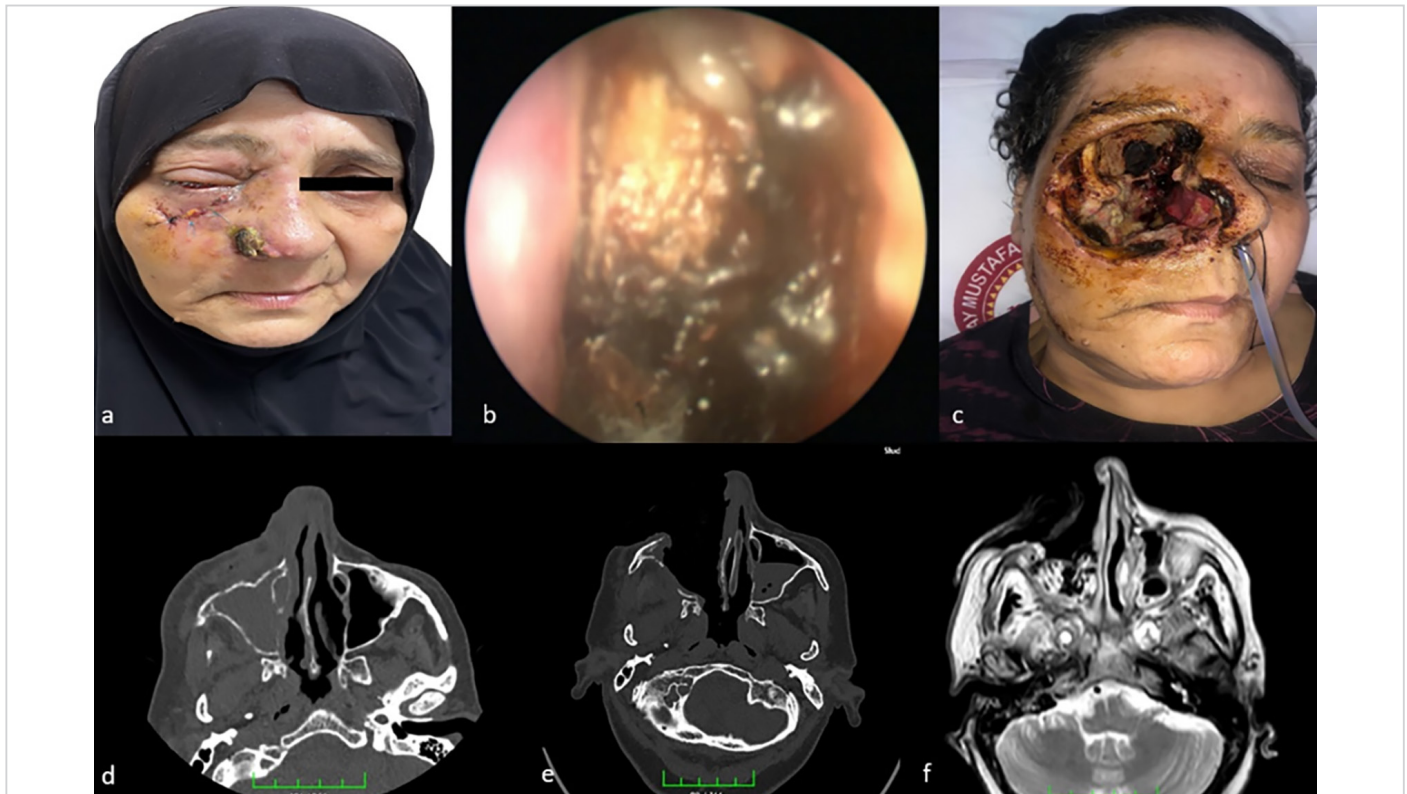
a) Image of an AIFR patient with skin involvement at presentation, b) endoscopic view of the same patient at admission, c) view of the operation site after surgical debridement, d) preoperative CT image of the patient. Periantral and premaxillary adipose tissue involvement and bone erosion and decalcification are worth noting, e) postoperative CT imaging f) postoperative MR imaging
